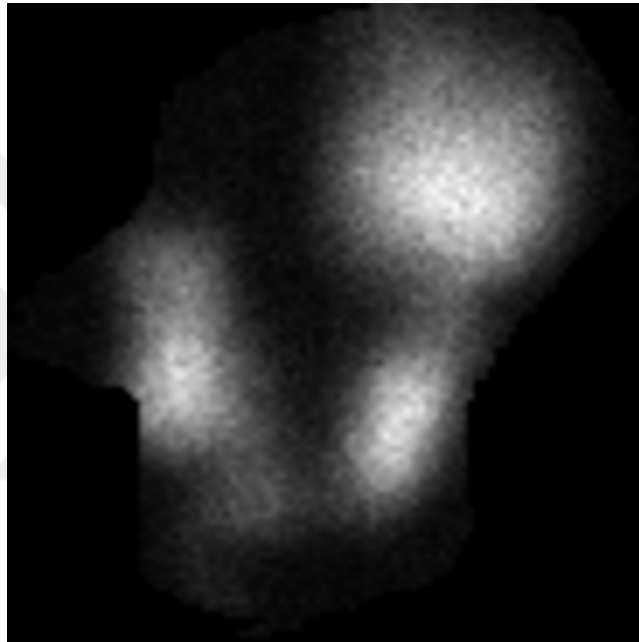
Demonstration of scintigraphic multinodular uptake image
